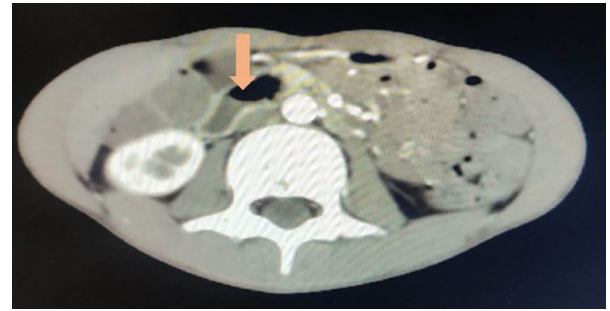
Contrast enhanced CT abdomen axial image with arrow showing compression of third part of duodenum leading to obstruction.
